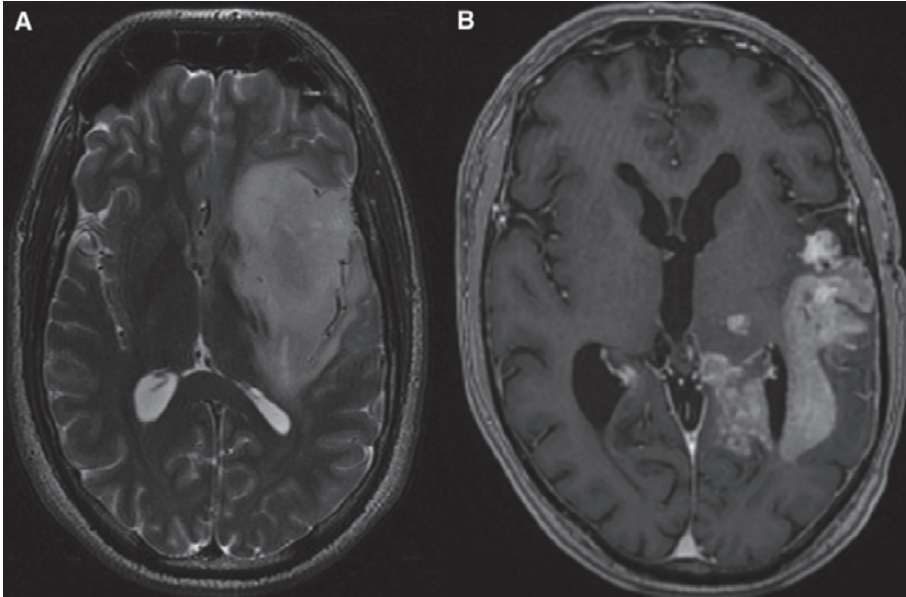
(A) Example of a low-grade glioma on a T2-weighted image. (B) Contrast enhancement of glioblastoma on a post-contrast T1-weighted image.
